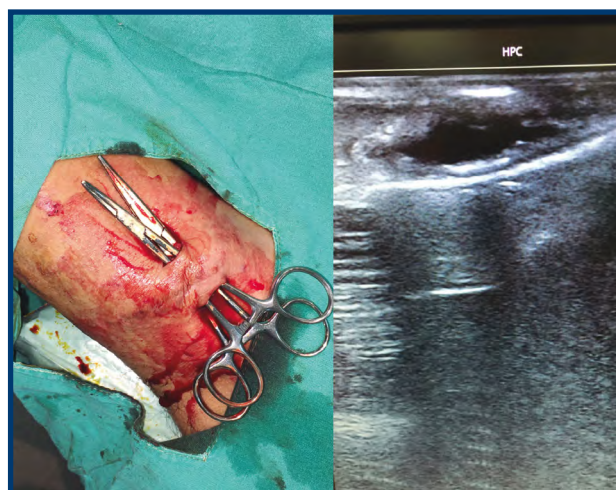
A AND B: Passage of the Halstead forceps through the two incisions, behind and in front of the fistula, under ultrasound guidance.
